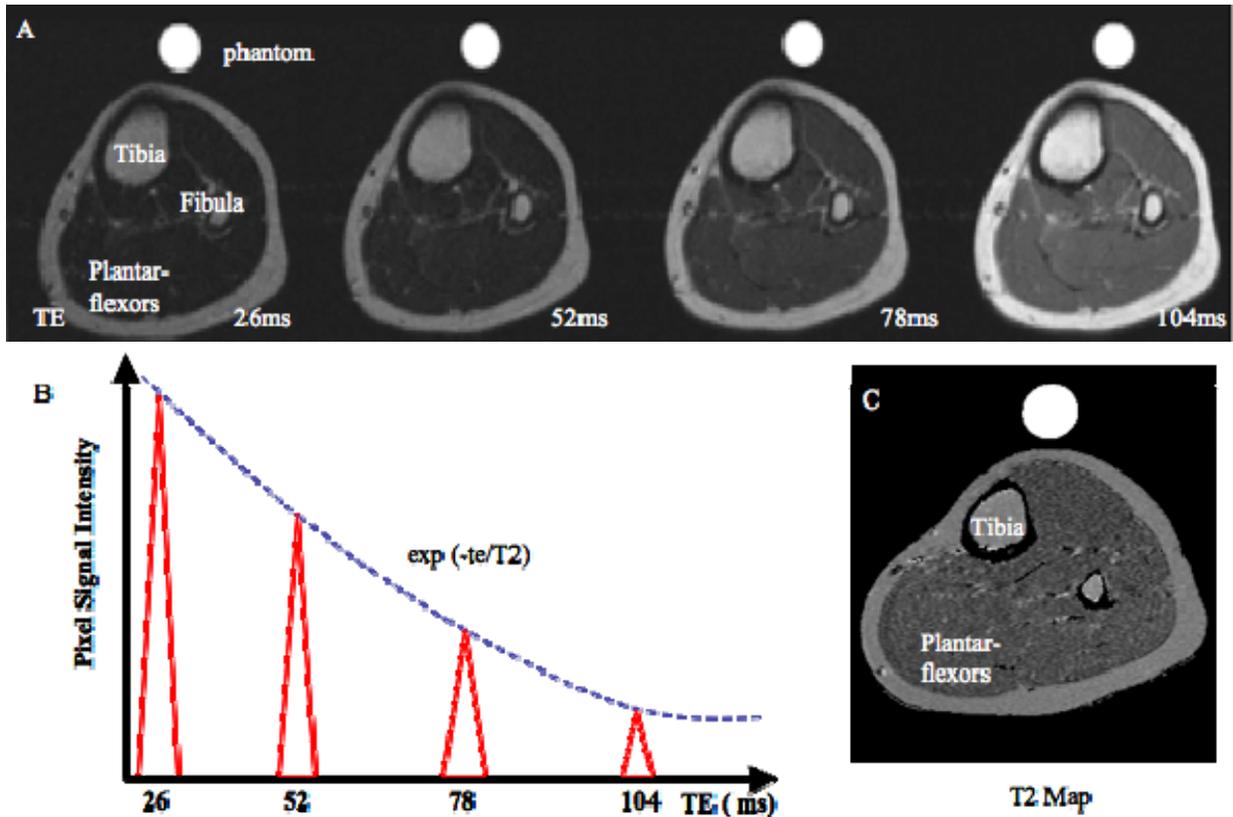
A) Representative ^1H -MRI T2 weighed images of the calf muscles obtained at four different echo times. B) Individual pixel signal intensities were fitted to an exponentially decaying curve along four different echo times (TE) C) Representative T2 map of the T2 weighted images acquired in A.
